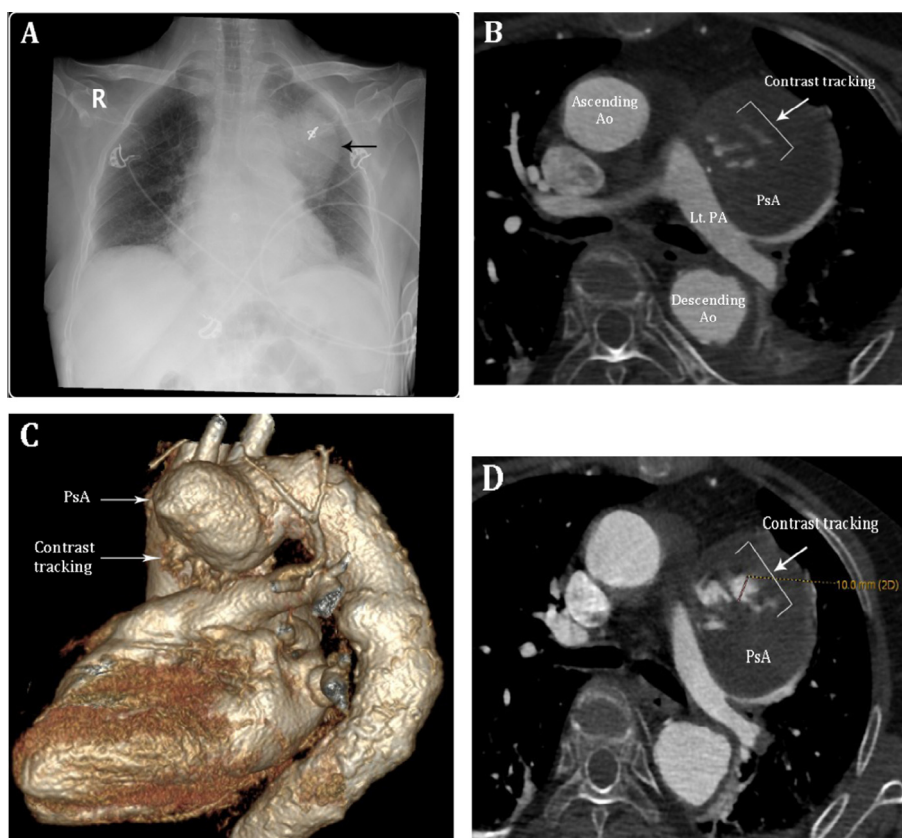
Preoperative chest X-ray and CTA: (A) chest X-ray showing widening of the mediastinum with left upper zone opacity (arrow); (B) and (C) initial CTA demonstrated saccular aortic-arch PsA with contrast tracking; (D) repeated CTA showing a minimal to mild interval increase in PsA size and contrast tracking. Ao = aorta; CTA = computed tomography aortogram; Lt. PA = left pulmonary artery; PsA = pseudoaneurysm.
